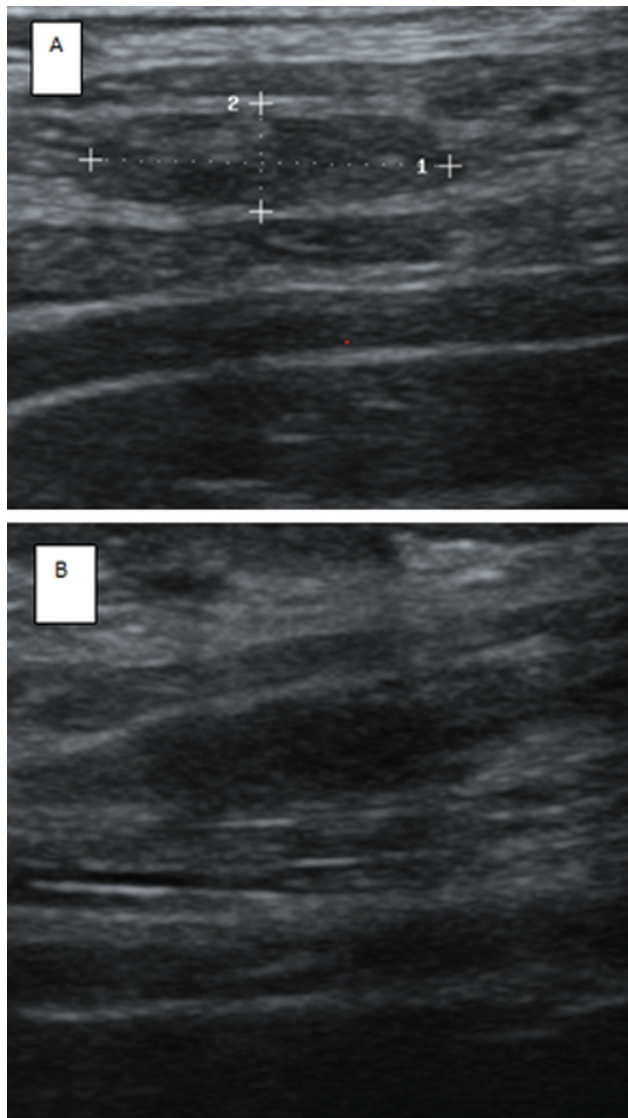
Ultrasound follow-up image 2 months post-percutaneous-aspiration-injection-reaspiration (PAIR) reveals near-complete resolution of the lesion. Residual lesion measuring $\sim 1.2 \times 0.4 \times 0.3$ cm on (A) longitudinal section and (B) transverse section.
